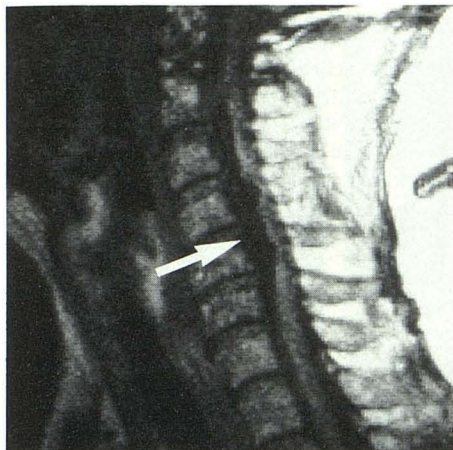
Sagittal MR image TE 32, TR 500 of cervical region shows lesion of low signal extending from C2 through C5 (arrow).
